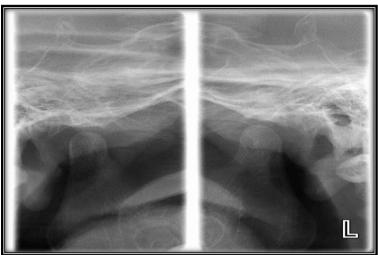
Panoramic temporomandibular joint (TMJ) radiograph of patient with myalgia reveals no significant pathological findings.
